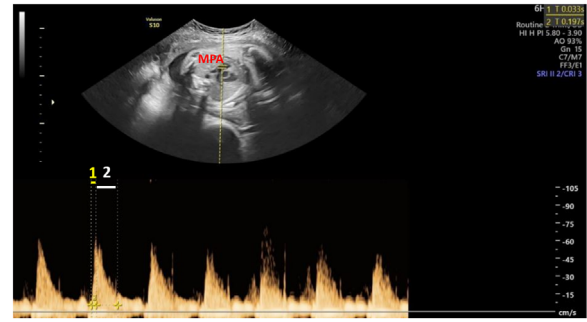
Main pulmonary artery (MPA) Doppler evaluation in the short axis view. 1: Acceleration time (AT), 1+2: Ejection time (ET)
